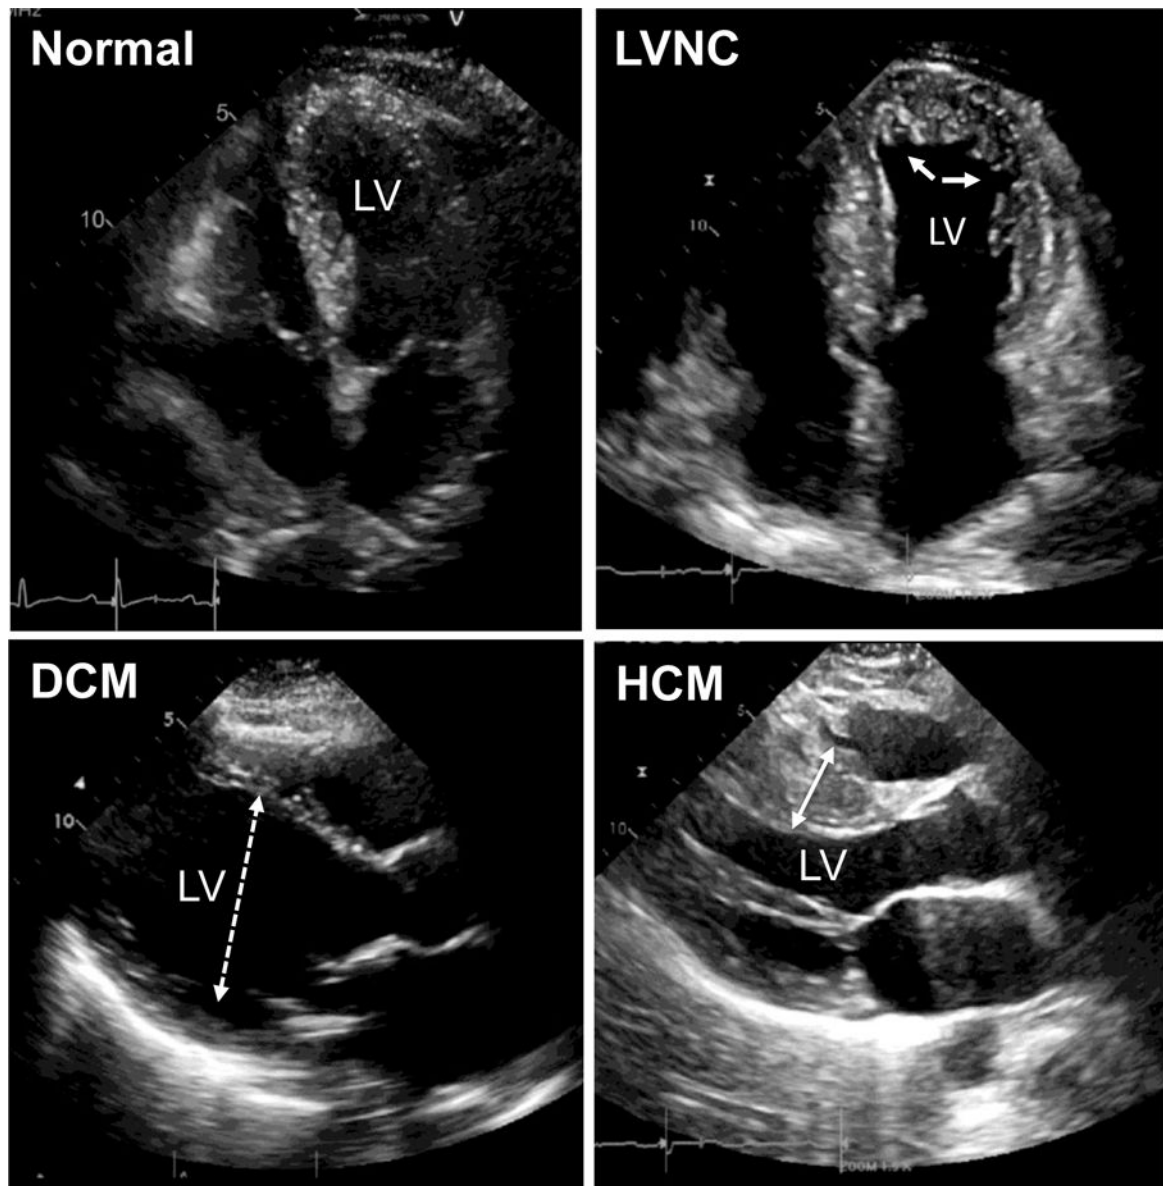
Echocardiography demonstrates forms of cardiomyopathy
